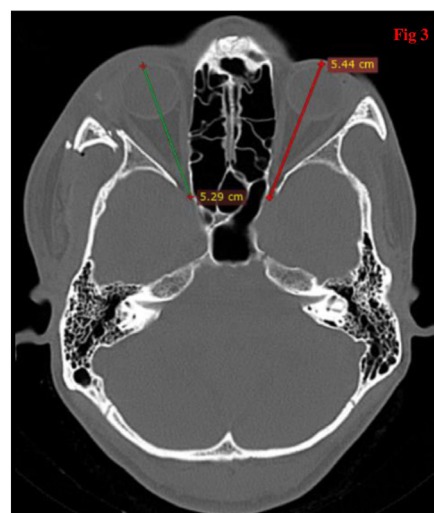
Pre operative linear measurement of enophthalmos in axial section of a CT scan
